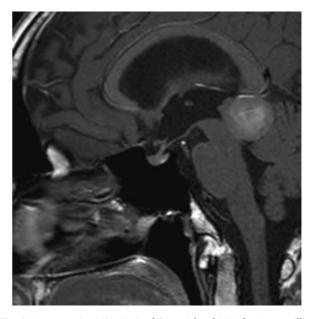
Preoperative MRI. Sagittal T1-weighted MRI showing an ill-defined pineal mass with spontaneous hyperintense areas.
